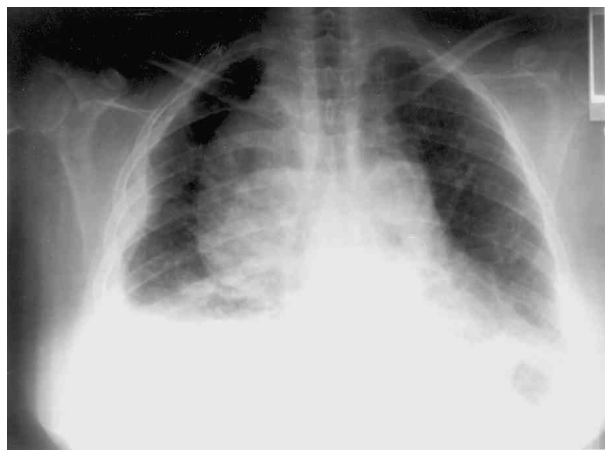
Portable chest AP radiograph showing loculated right pleural effusion and large right mediastinal mass.
